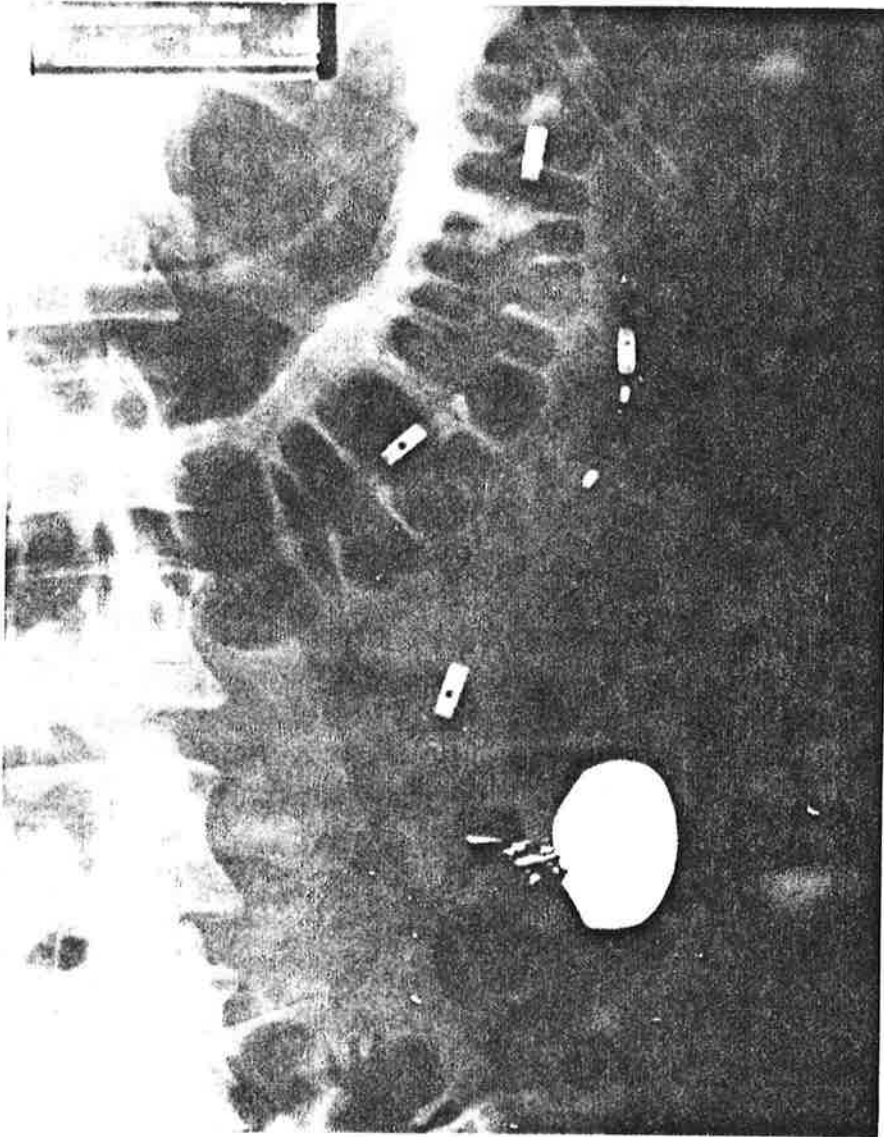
Radiograph showing the position of the catheters in the small intestine.
